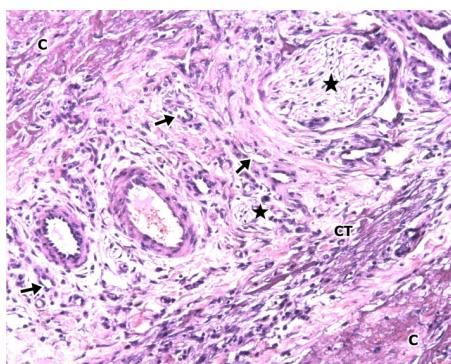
Malformed tooth germ (stars), calcification (C), capillaries (arrows) and connective tissue (CT), $\times 100$, H/E.
